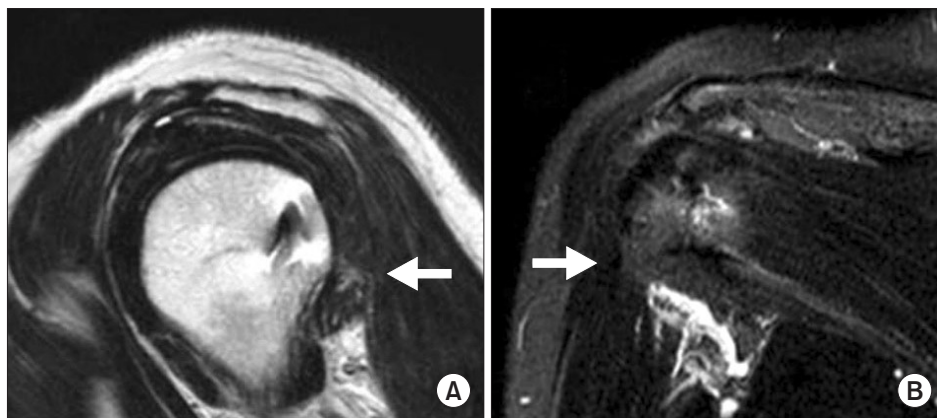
Postoperative magnetic resonance imaging at 9 months showing good healing at the repair site (arrows). (A) Sagittal view. (B) Oblique coronal view.
